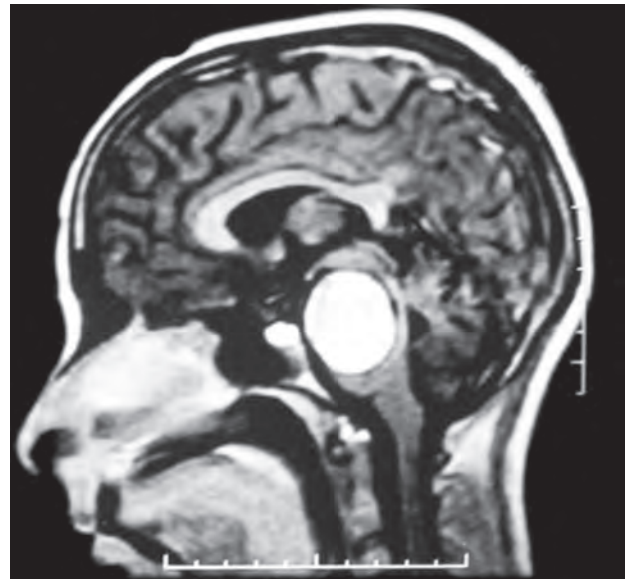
Contrast enhanced MRI of brain showing giant distal basilar artery aneurysm
